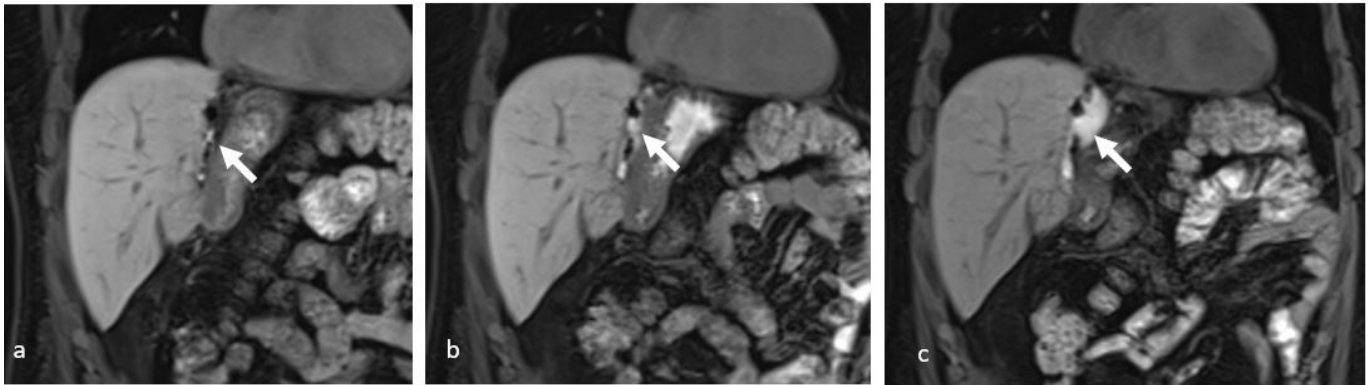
Coronal T1-weighted MR images in a left-lobe donor demonstrate progressive contrast extravasation along the hepatic resection margin on delayed imaging at 30 minutes (a), 60 minutes (b), and 6 hours (c) after administration of a hepatocyte-specific contrast agent, compatible with active biliary leakage (arrows).
